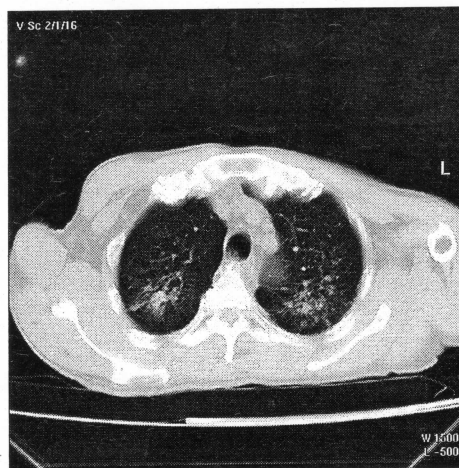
The same patient to fig. 4.5. chest CT show active PTB in bilateral upper lobes
